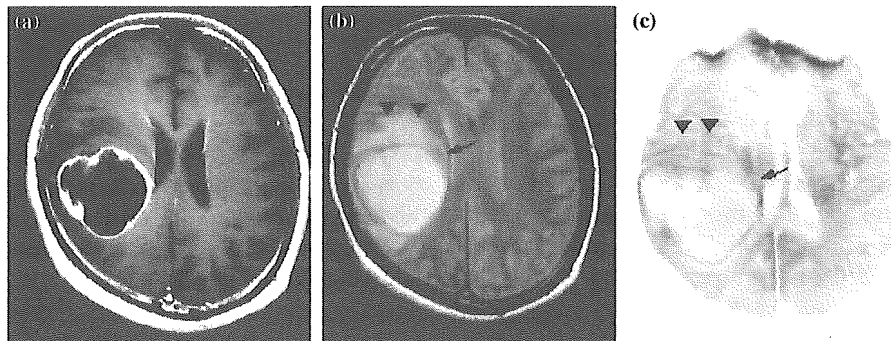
Conventional MRI and 3DAC in Case 10. (a) Gd-T1WI demonstrates a cystic-shaped glioblastoma situated in the right parietal lobe. (b) PDWI shows a hyperintense focus in the corona radiata as the responsible tract (arrow), and subcortical white matter surrounding the tumor, suggesting a perifocal edema (arrowhead). (c) 3DAC demonstrates no change in color for both corona radiata (arrow) and subcortical white matter surrounding the tumor, corresponding to a hyperintense focus on PDWI (arrowhead). Fluid within the cystic lesion is shown as an area of whiteout, as is cerebrospinal fluid within the lateral ventricle.
